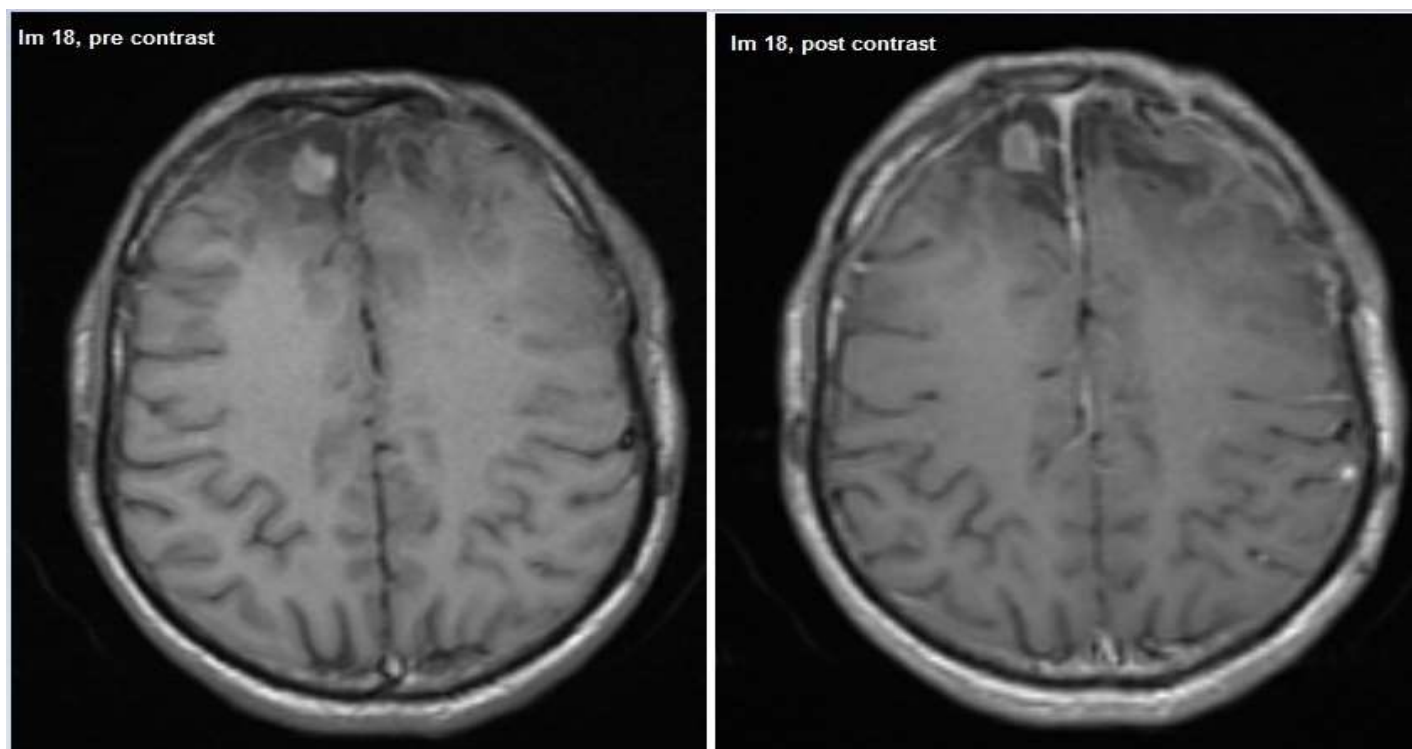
MRI image pre and post contrast -show Mix enhancement
